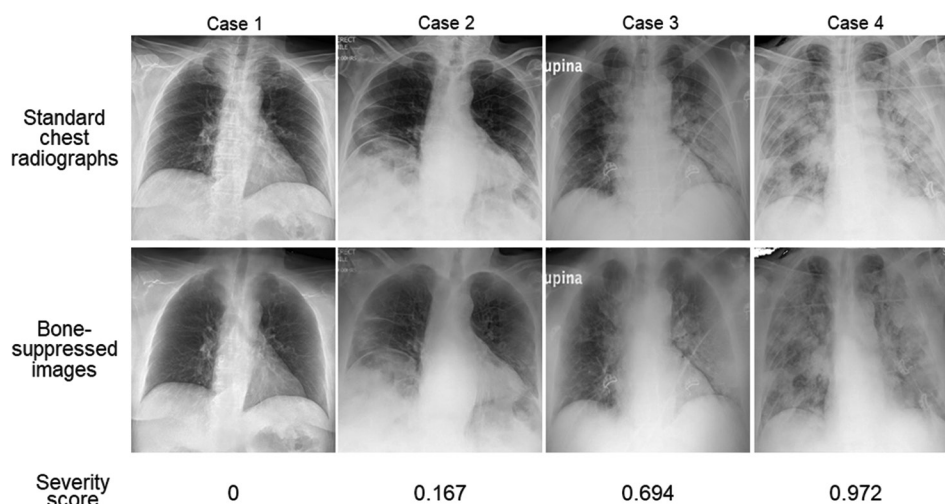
Examples of standard chest radiographs from a publicly available coronavirus disease 2019 database, along with the corresponding bone-suppressed images produced by our artificial intelligence model. The severity scores based on the Brixia score are displayed at the bottom of each image pair.
